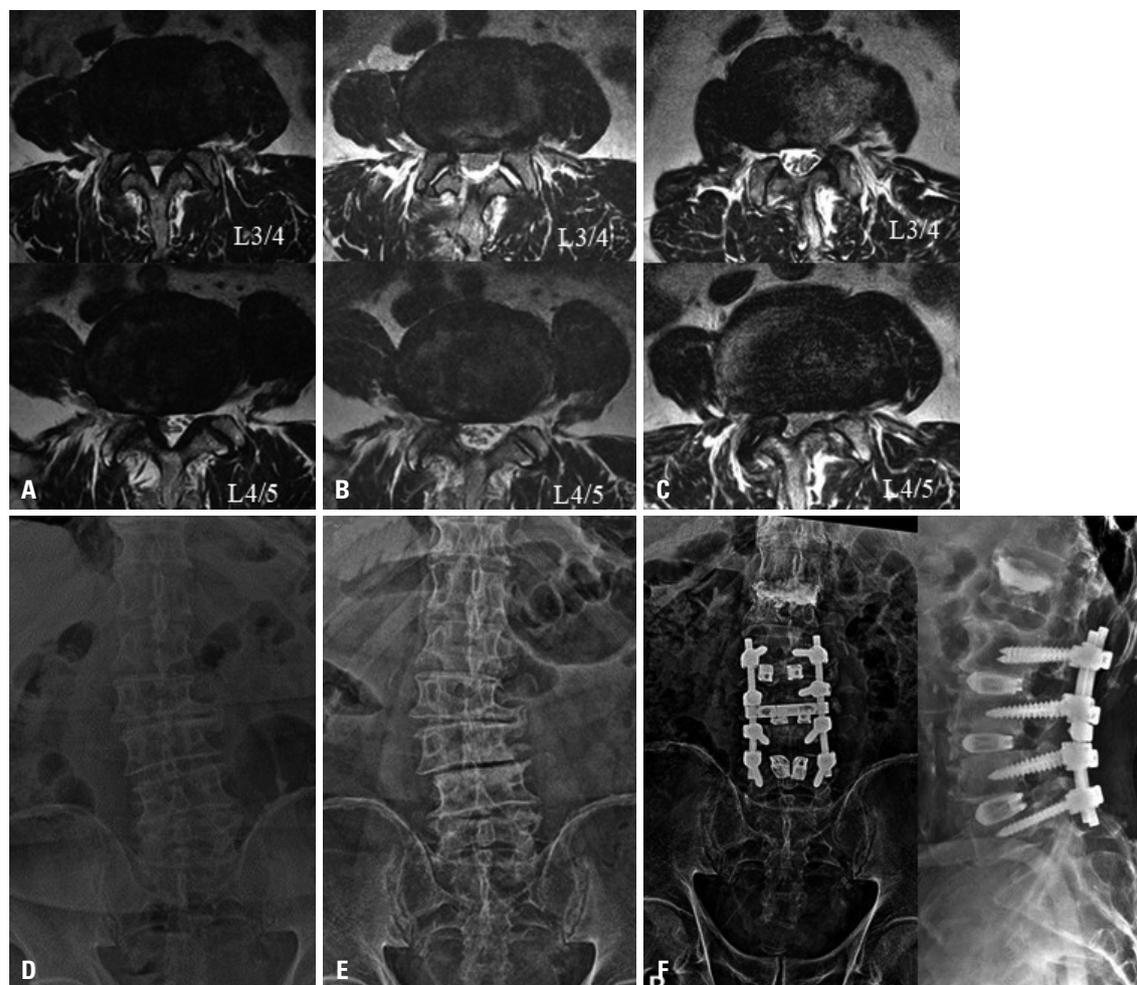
Restenosis and lateral slippage of the vertebral body following UBE with two levels of decompression. A 74-year-old male patient presented with lower back pain, bilateral leg pain, and numbness that were more pronounced on the right side. (A) Axial T2W MRI revealed a bony spur, facet hypertrophy, foraminal stenosis, and herniated disc protrusion at levels L3–4–5. (B) Axial T2W MRI obtained the day after UBE showing thecal sac decompression at L3–4–5. (C) The patient complained of severe pain in the right leg and back 12 months after surgery. MRI revealed restenosis, foraminal stenosis, and severe L5 nerve compression. (D) Initial lumbar spine anteroposterior radiograph. (E) Lateral slippage of the vertebral body is observed. The patient had no history of osteoporosis or falls within the previous 12 months. (F) PLIF was performed at levels L2–L5, and vertebroplasty at L1 due to a slight compression fracture of the superior endplate of L1. The right leg and lower back pain improved postoperatively. PLIF, posterior lumbar interbody fusion; T2W, T2-weighted; UBE, unilateral biportal endoscopic discectomy.
